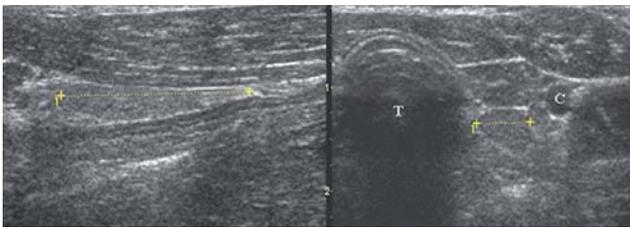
Longitudinal and transverse ultrasound images of a normal canine left thyroid lobe (in between calipers). T = trachea, C = common carotid artery.
